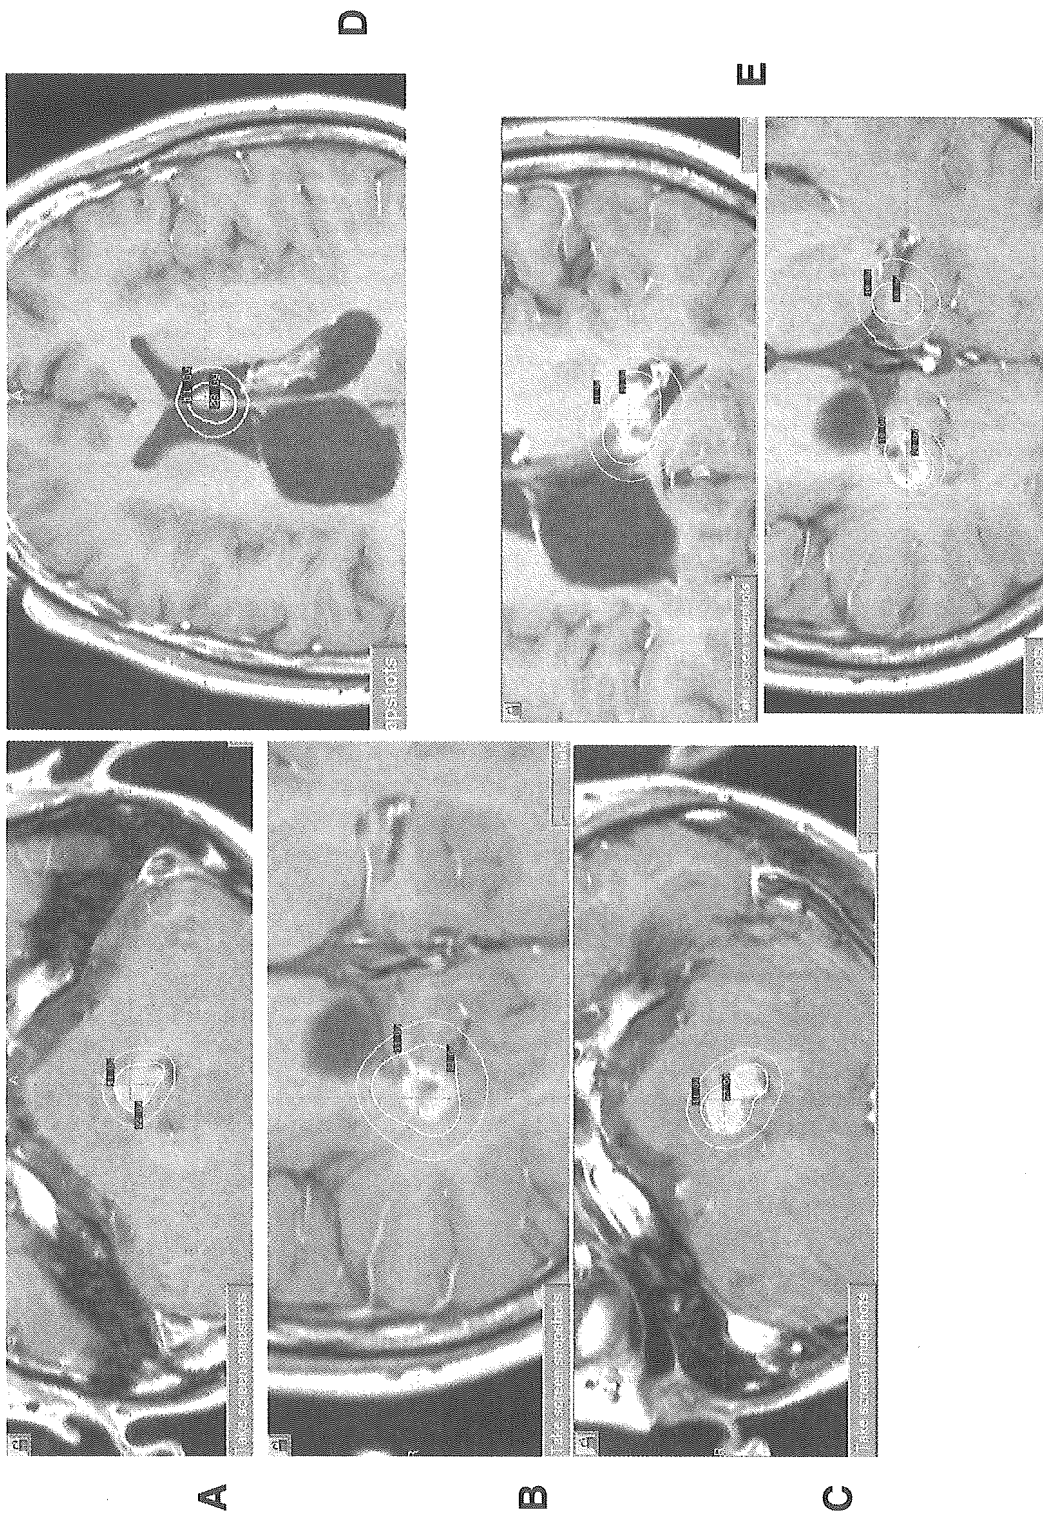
Case 1: Axial T1-weighted MR images with gadolinium-diethylenetriaminepenta-acetic acid displayed on workstations running the Leksell GammaPlan program. (A) First Gamma knife (GK) radiosurgery for fourth ventricular dissemination. (B) First GK radiosurgery for dissemination in the right trigone. (C) Second GK radiosurgery for fourth ventricular dissemination. (D) GK radiosurgery for dissemination in the septum pellucidum. (E) Second GK radiosurgery for left lateral ventricular dissemination
